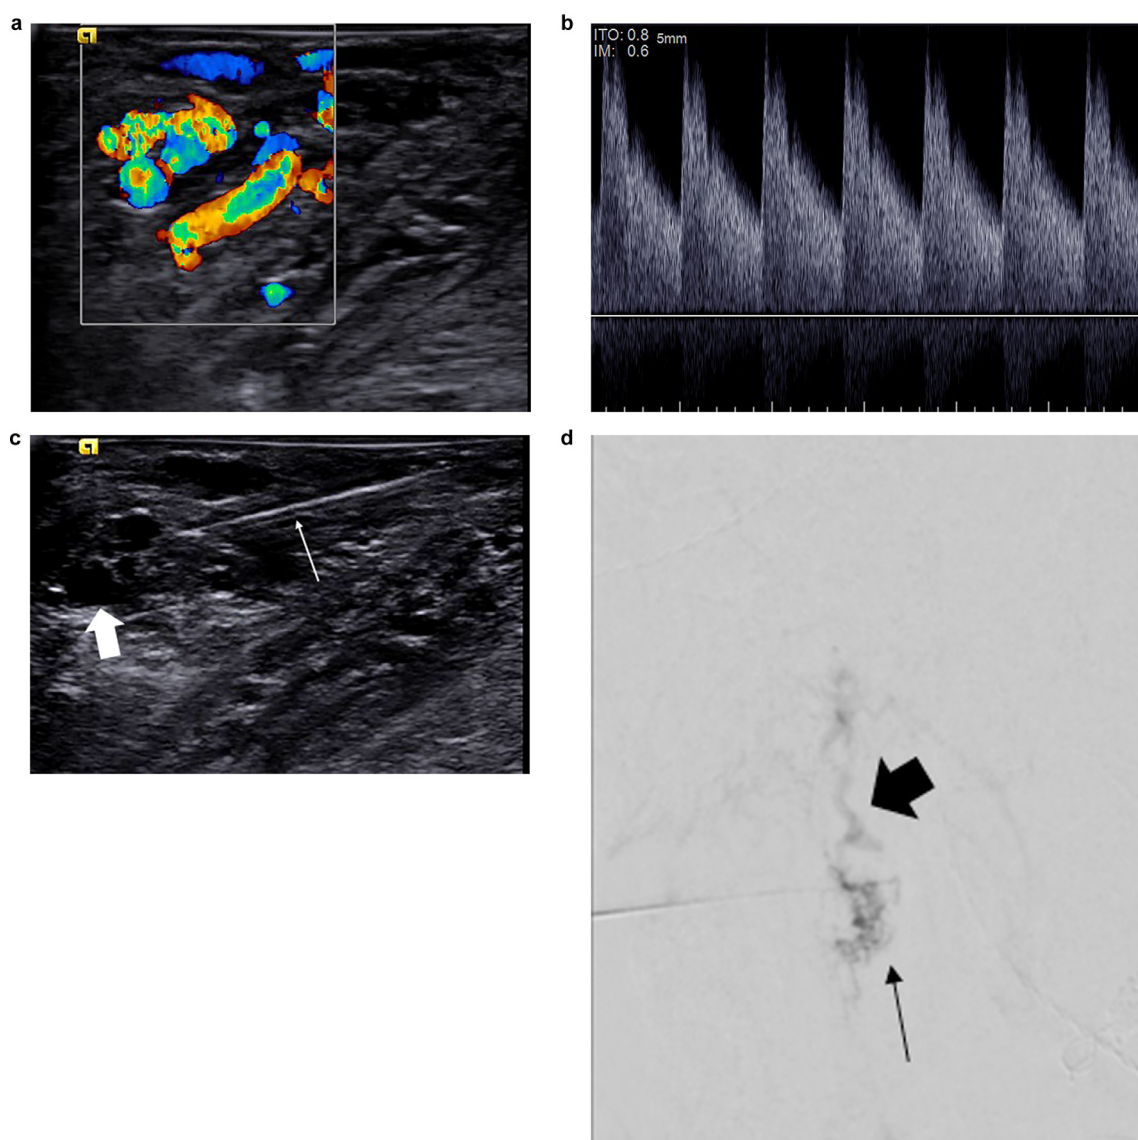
Patient with a large AVM of the left mandibular and the floor of the mouth. (a) Color Doppler examination of the floor of the mouth showing a fast flow vascular network with aliasing. (b) High systolic and diastolic velocities are observed on spectral Doppler examination. (c) Direct puncture (needle shown on small arrow) of the nidus (large arrow) under combined B-mode and color Doppler ultrasound guidance. (d) DSA showing the nidus (small arrow) and the draining vein (large arrow).
